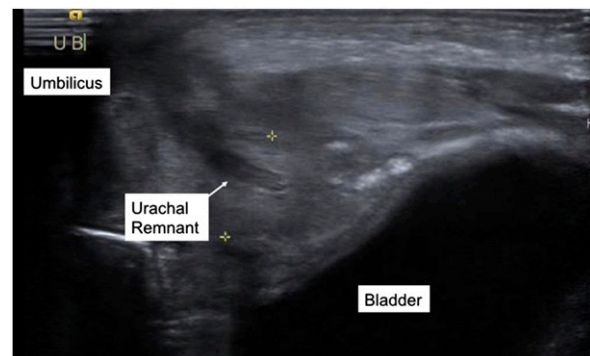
Ultrasonographic scan of abdomen reveals tract from bladder to umbilicus (ie, urachal remnant).
